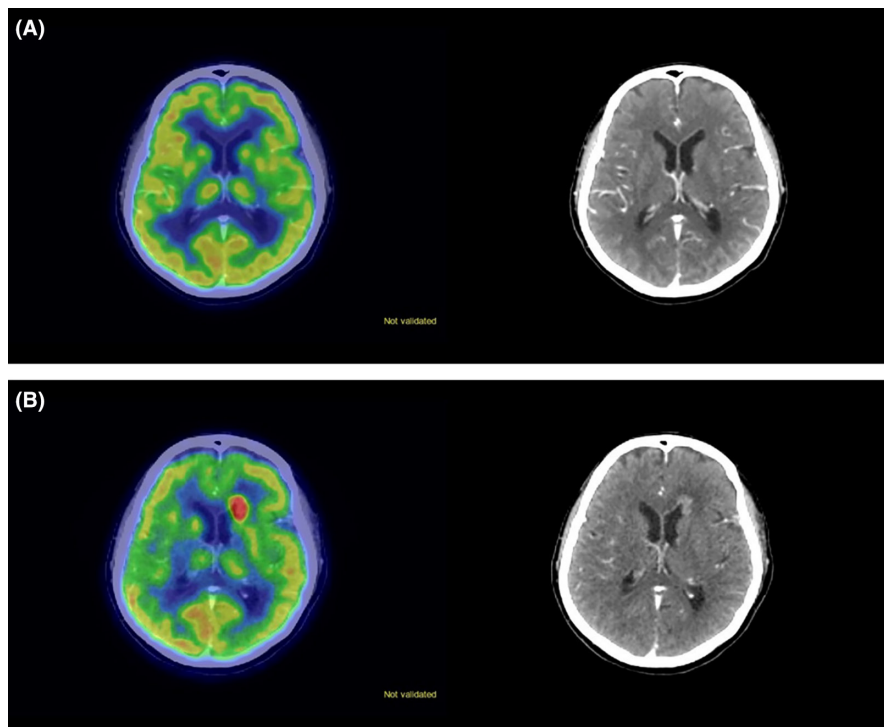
(A) PET CT scan and CT scan on 21 October 2021 showing no nodule; (B) PET CT scan and CT scan on 25 April 2022 showing nodule on left anterior horn.
